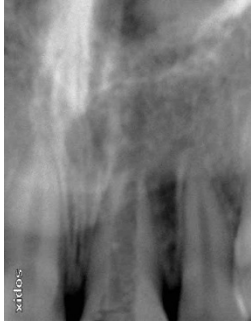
Tooth with incompletely formed root; wide root canal, thin canal walls and extensive periapical lesion.
